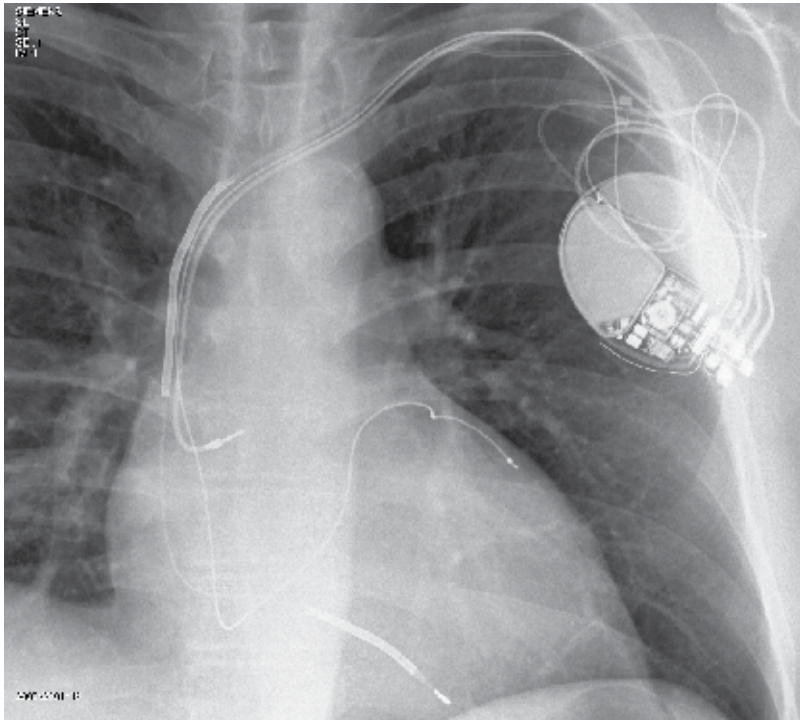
Chest X-ray showing implantation of 3 leads including a left ventricular lead placed in a branch of the coronary sinus (cardiac resynchronisation therapy).
